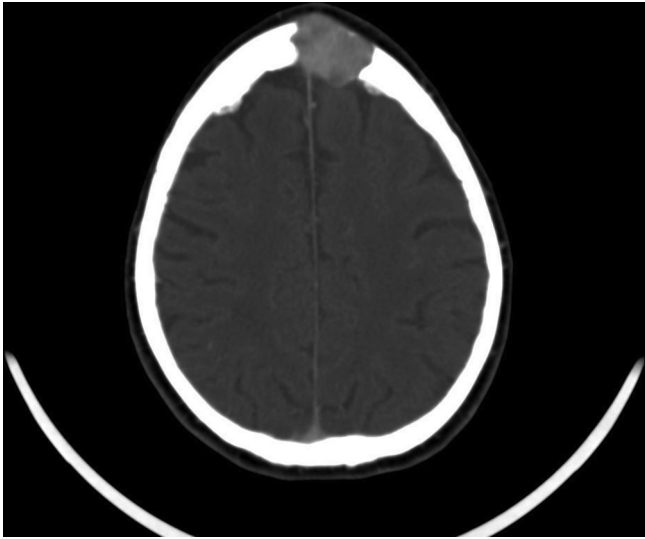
Pre-operative Imaging. CT with contrast axial view. Note the enhancing lesion eroding through the frontal bone.
